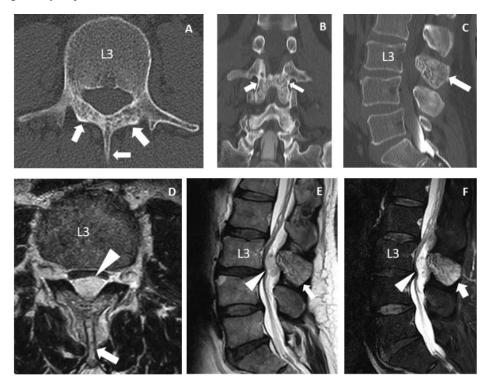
Images obtained at the previous hospital. Computed tomography (CT) scan (A) and CT myelograms (B, C) showed abnormal translucent signals (white arrows) at the L3 spinal processes and laminae. Magnetic resonance images (D–F) showed an epidural mass lesion (white arrowheads) at the same level. This well-demarcated lesion seemed to be isolated from the intraosseous lesions (white arrows).
